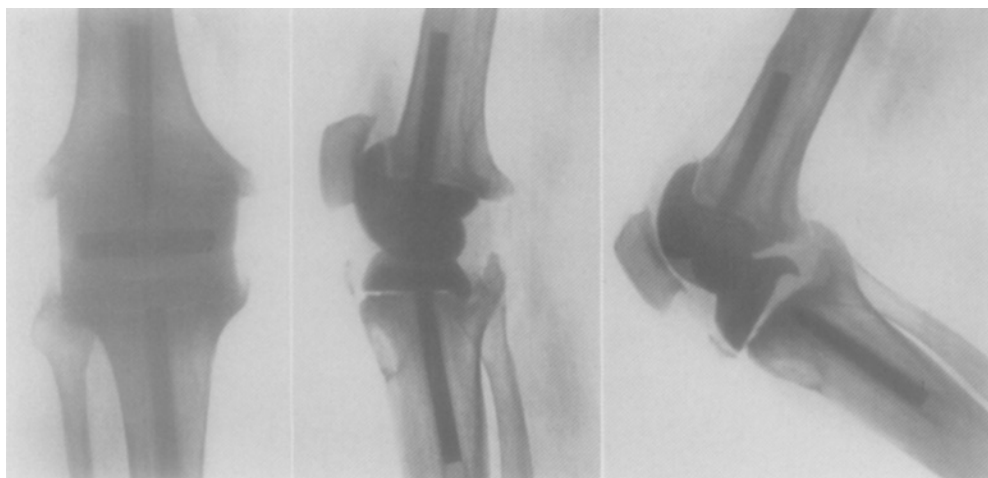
Case 23: roentgenograms of right knee 1 year 2 months after arthroplasty.
